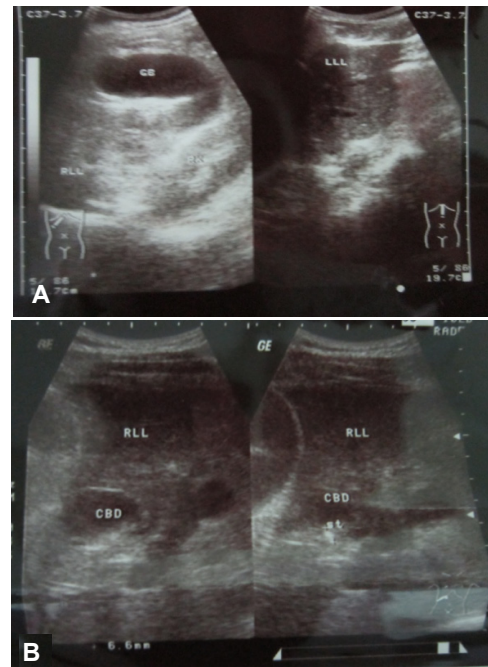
Abdominal ultrasound showed dilatation of intrahepatic bile duct and a distended gallbladder contained gallbladder sludge (A) and dilatation of extrahepatic bile duct (B)
